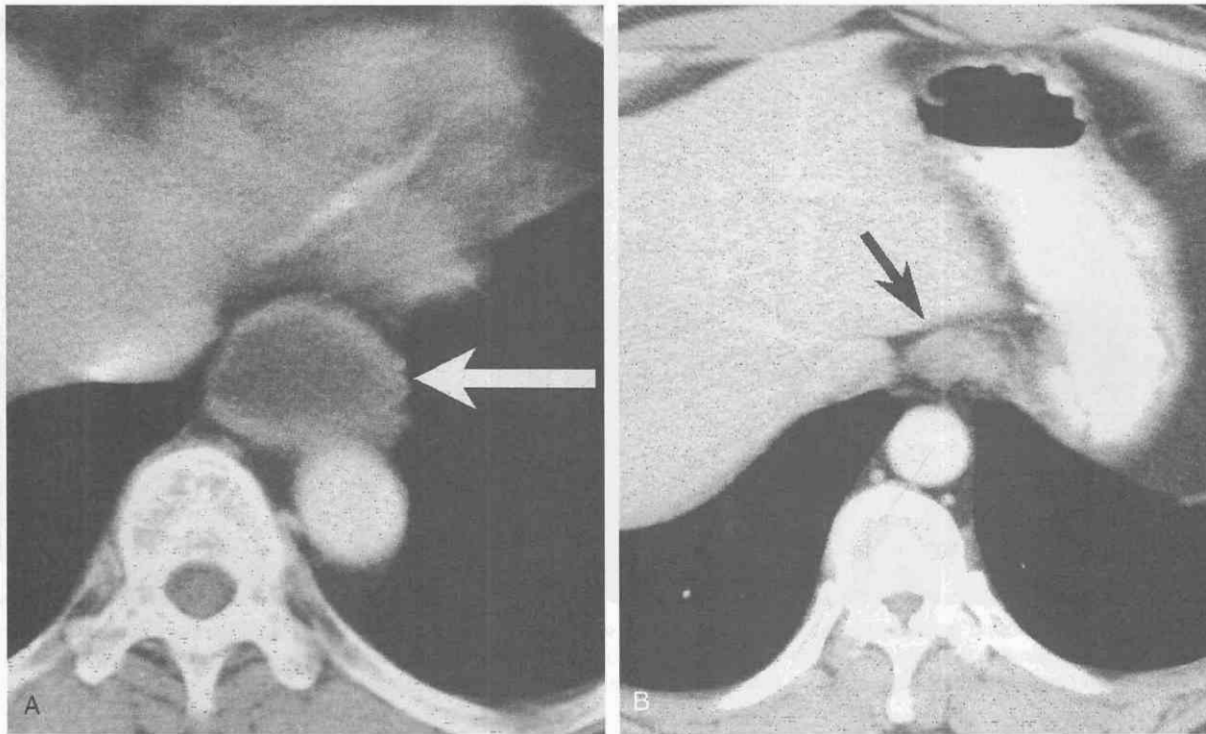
Achalasia in a 47-year-old woman. *A*, CT scan shows dilated, fluid-filled esophagus (arrow). *B*, In this patient, the distal esophageal wall thickness (arrow) is normal, in contrast with other obstructive causes of the esophagus.
